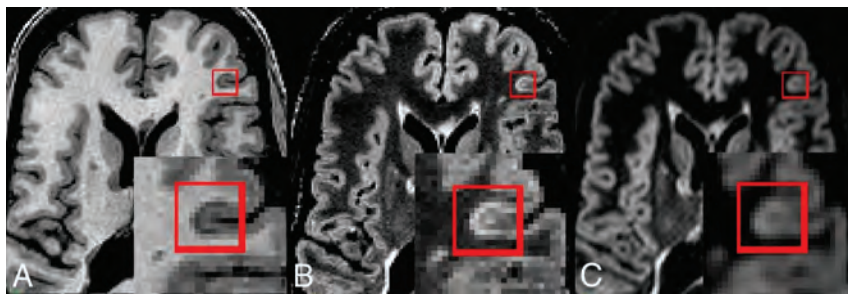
Cortical lesions not apparent on DIR: T1-weighted (A), FLAIR (B), and DIR (C). CLs affecting the cortex are marked with a red square and zoomed. Note the clear hypointense signal on the T1-weighted image and the clear hyperintense signal on FLAIR images. The lesion is less evident on DIR because it is only slightly hyperintense compared with surrounding cortex, possibly due to greater partial volume effects than in FLAIR.
